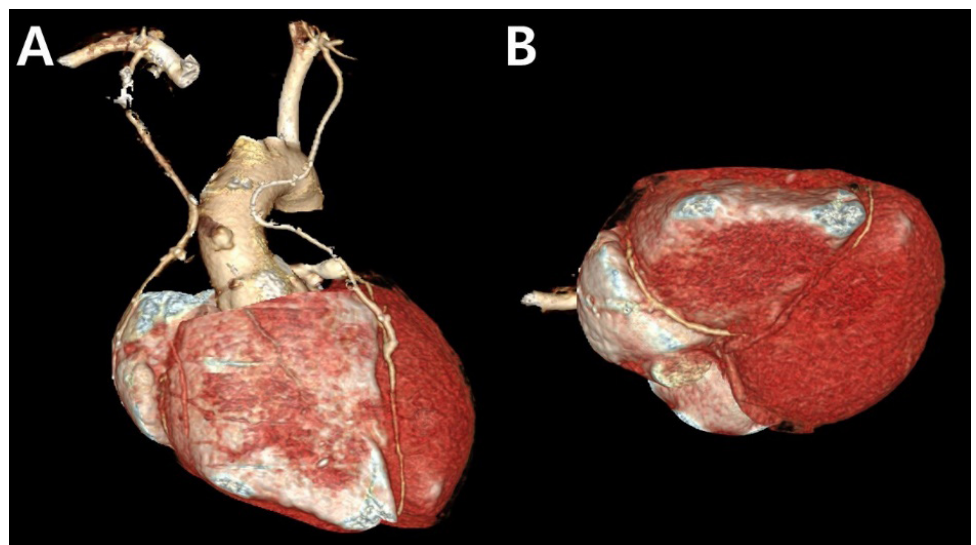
Postoperative computed tomography angiography findings 1 year after the operation show patent left internal thoracic artery (ITA) and right ITA grafts in patient 3. (A) Anterior and (B) inferior view.
